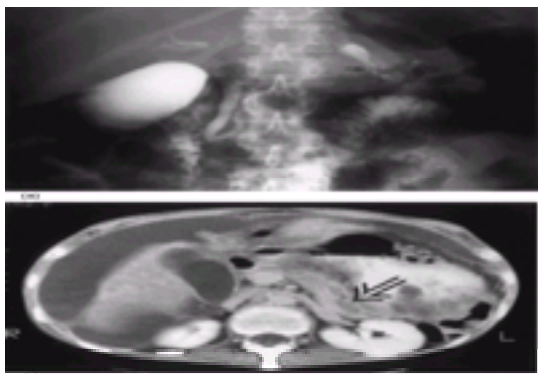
(a) An ERCPgram showing the leakage point of a pancreatic fistula from the distal disrupted pancreatic-duct system (arrow); (b) a computed tomogram of the same patient shows the rupture area in the distal pancreatic duct (arrow) and ascitic fluid, particularly around the liver.
